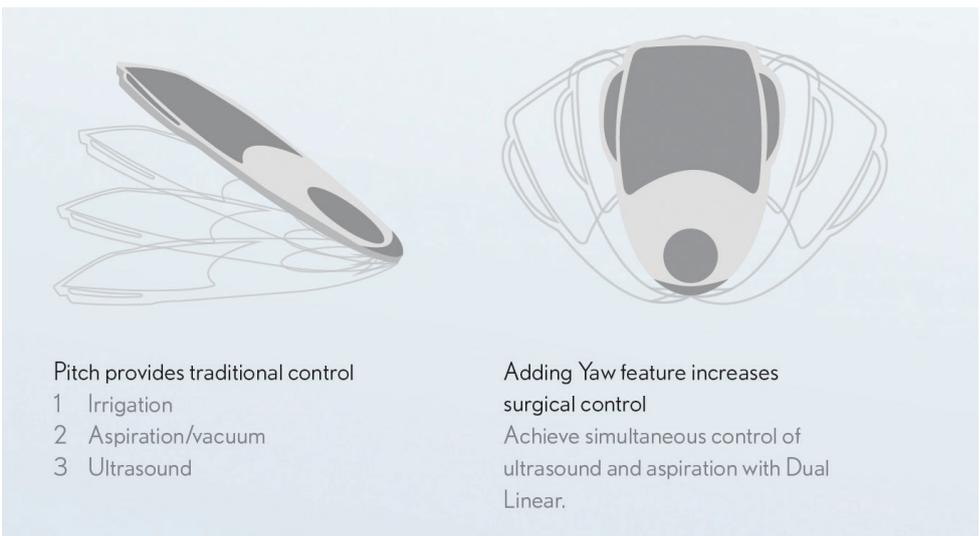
The Stellaris Elite has a dual-linear footpedal (left) with several interesting features, including the ability to uncouple control of the ultrasound power and fluidics (right).
